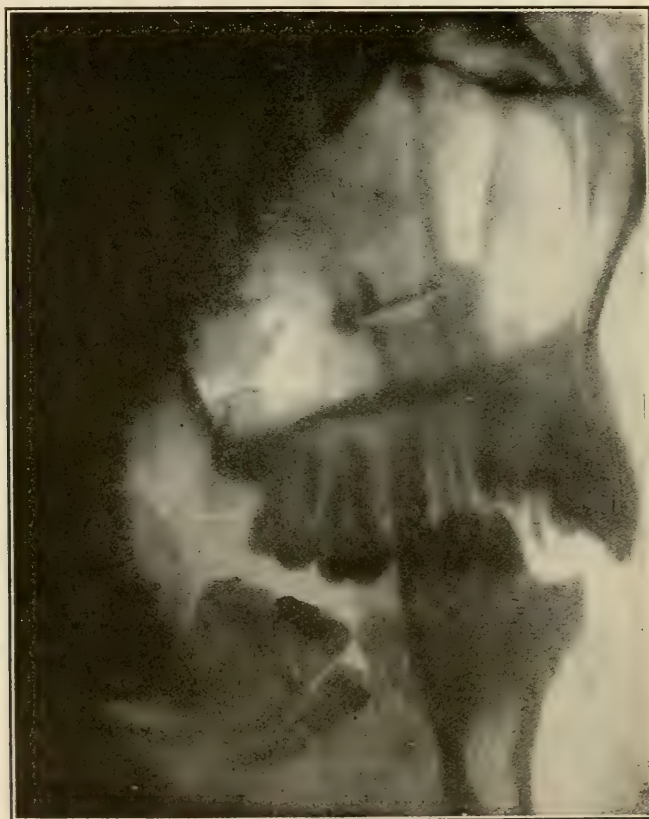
A badly impacted lower second bicuspid, with no space at all for it in the dental arch. (Radiograph by Pancoast of Philadelphia.)
